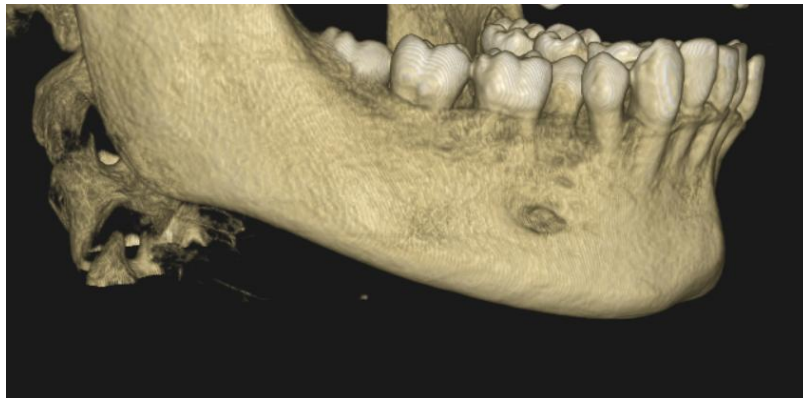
A Full Mouth CBCT scan; B. Area of interest (Mandibular buccal Shelf)
